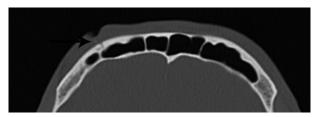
Noncontrast computed tomography scan of the sinuses shows complete removal of the TASER dart.
